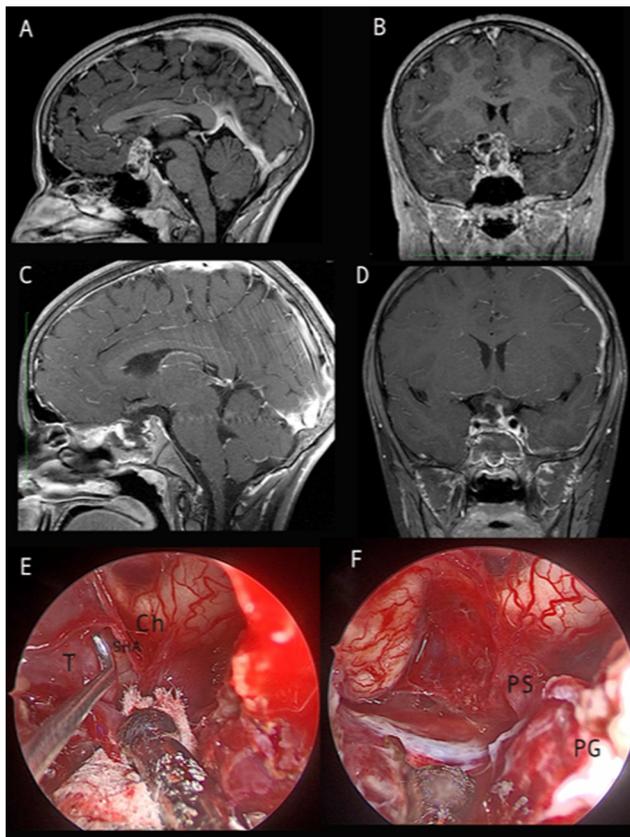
Preoperative (a, b) and postoperative (c, d) MRI of a supradiaphragmatic craniopharyngiomas operated on by extended EEA, achieving a gross total resection. The close-up view offered by the endoscope discloses the tumor-optic nerves interface and surrounding vessels (e). At the end of the removal, the preserved pituitary stalk resulted free from the tumor (f). Ch optic chiasm, PG pituitary gland, PS pituitary stalk, SHA superior hypophyseal artery, T tumor
